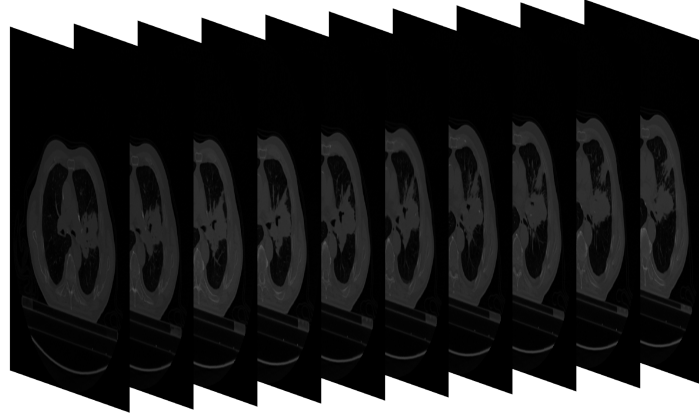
Example of CT scans of patient LUNG1-001 of NSCLC-Radiomics dataset.
